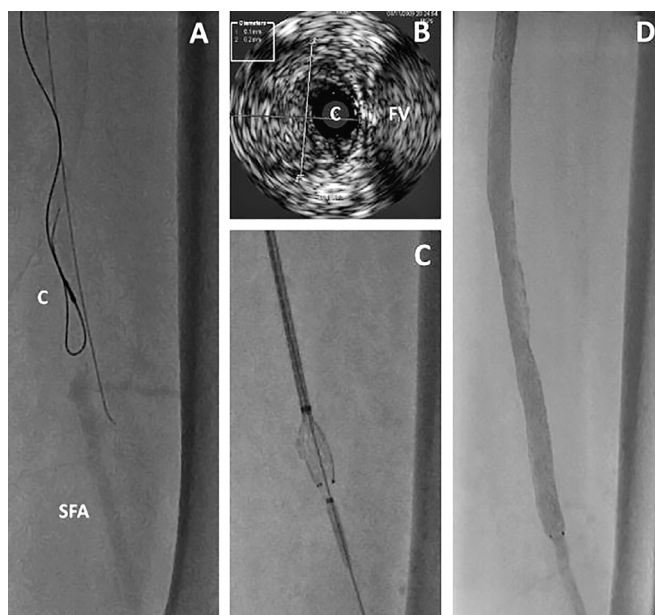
Intravascular ultrasound (IVUS) used to assess the intra-arterial location while traversing a long occlusion: A — the IVUS catheter (C) is seen over a looped wire in an occluded segment of the mid superficial femoral artery. An adjacent wire is extra-arterial. SFA indicates the distal superficial femoral artery beyond the occlusion; B — IVUS image showing the catheter (C) in the middle of the artery and adjacent to the femoral vein (FV). The diameter of the artery was 6.1×6.2 mm, which represents to media and intima and likely overestimates the reference lumen diameter; C — stent deployment after successfully traversing the occluded artery; D — final result on angiography
